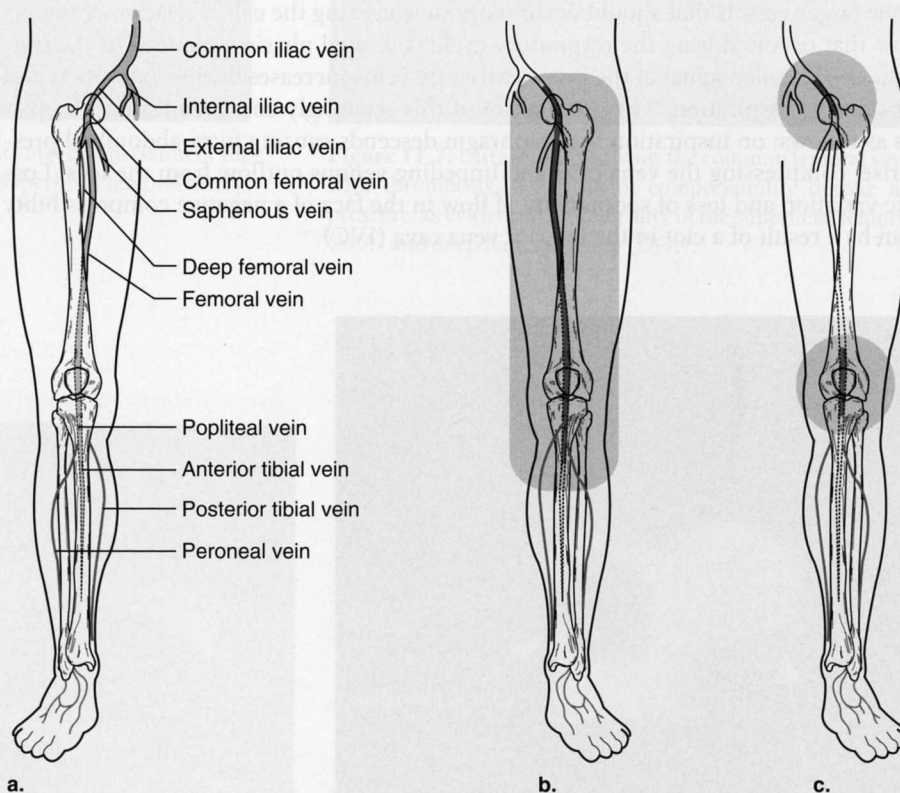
The venous system of the lower extremity (A). The entire system is visualized by traditional studies (B). The more focused exam for emergency ultrasound targets the inguinal and popliteal regions (C).
